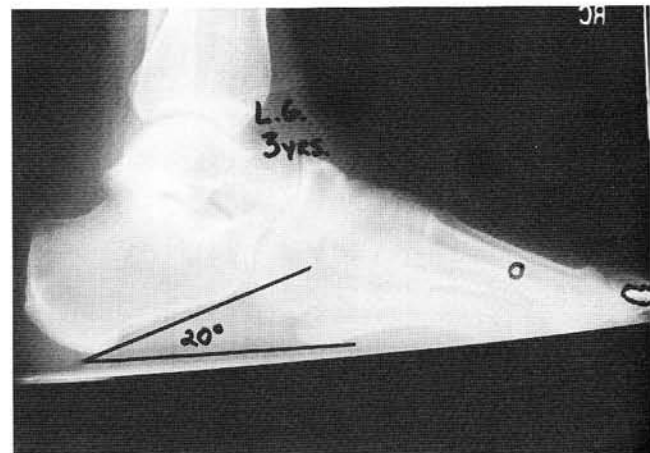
Three year postoperative lateral radiograph.
